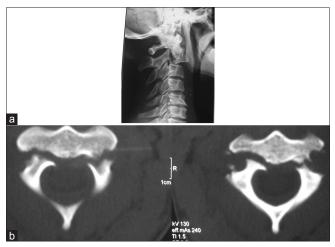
(a) Hangman's fracture (bilateral pars interarticularis fracture) on X-ray image. (b) Axial CT showing Hangman's fracture (parsinterarticularis fracture)
